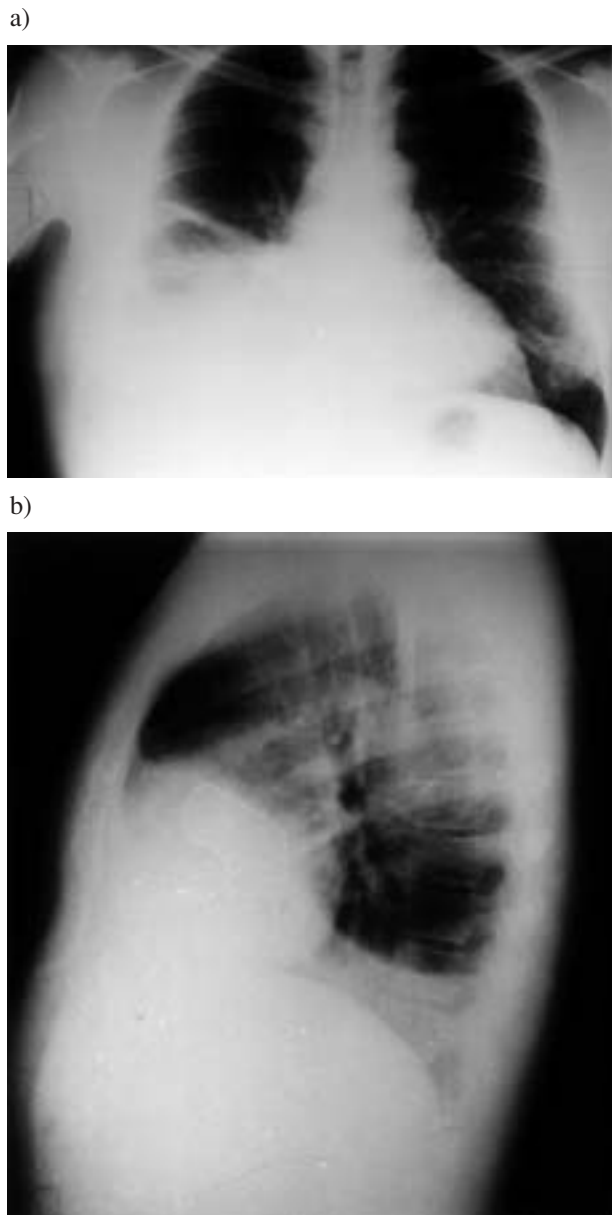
a) Posteroanterior; and b) lateral chest radiographs showing infiltration of the lower right lung and pleural effusion.
